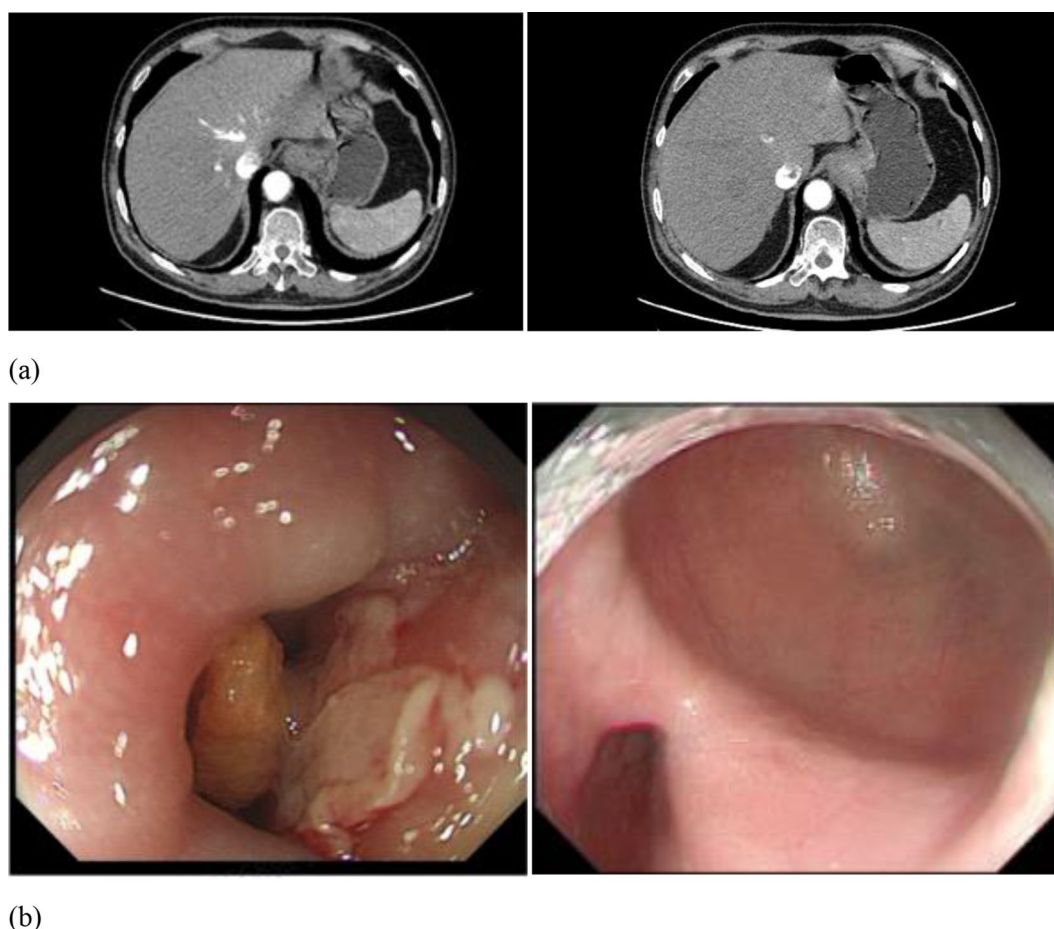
Preoperative examination. (a) The enhanced computed tomography (CT) images. (b) The gastroscopy images
